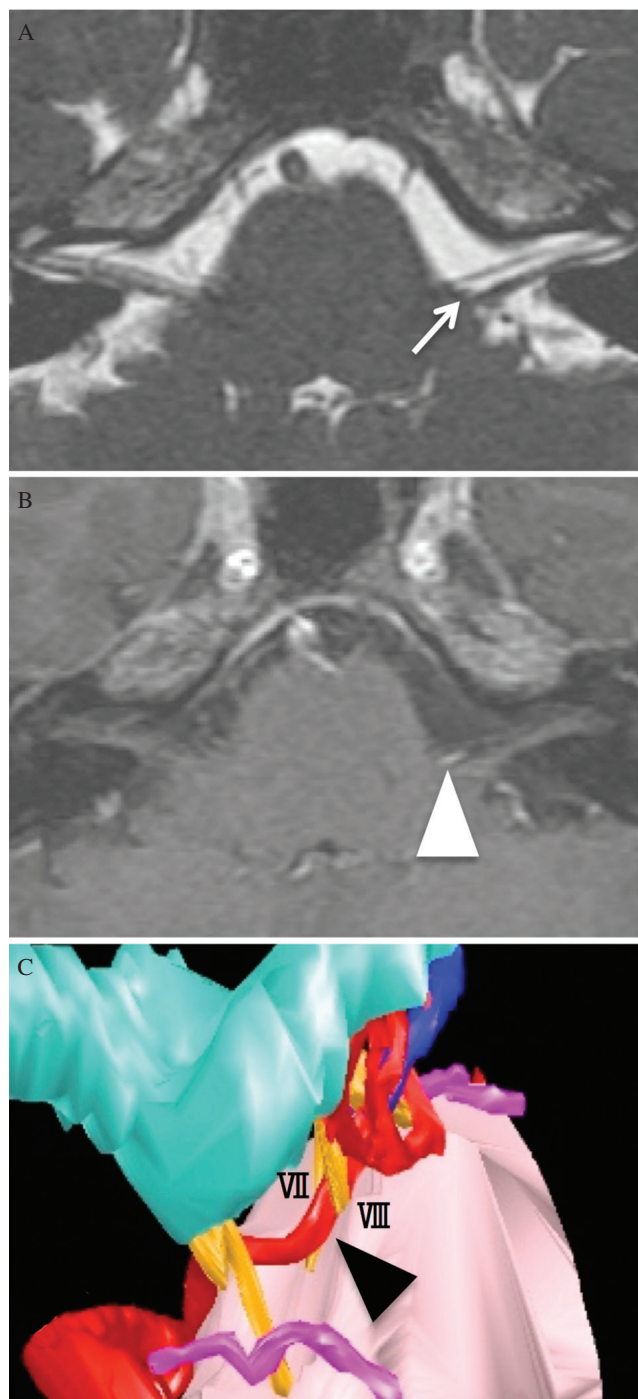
Preoperative magnetic resonance imaging (MRI) and three-dimensional image constructed by GammaPlan®. (A) MRI (fast imaging employing steady-state acquisition) of the complex of the seventh and eighth cranial nerves shows the widened space between the seventh and the eighth nerves (white arrow) on the affected side. The nervus intermedius is invisible. (B) Contrast-enhanced MRI (T1-spoiled-gradient-recalled) revealed neurovascular contact at the root entry zone (REZ) of the vestibulocochlear nerve (white arrowhead), suggesting compression on the REZ of the nervus intermedius. (C) Three-dimensional image of the surgeon's view via the left retrosigmoid approach clearly demonstrates the anatomical relationship between the anterior inferior cerebellar artery (AICA, black arrowhead) and the complex of the seventh and eighth cranial nerves.
